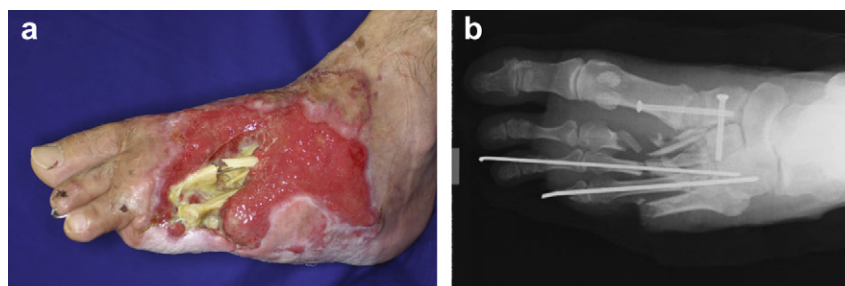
Appearance of the foot 2 months after injury. (a) Upon visual inspection, exposure of the third and fourth metatarsals and amputation of the fourth and fifth toes were observed. (b) Upon radiographic examination, fracture of the second and third metatarsals was observed, and the bones appeared fragmented.
